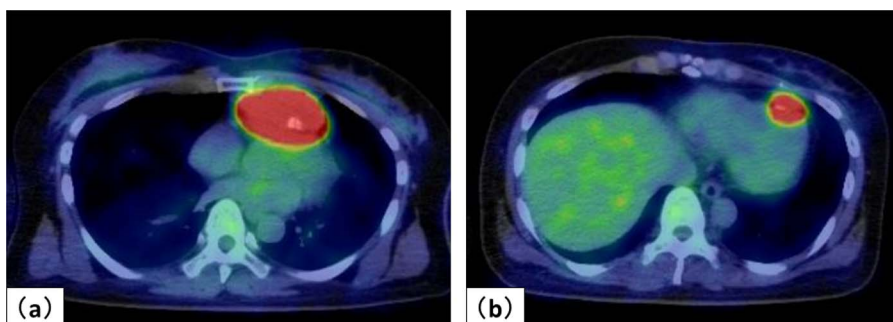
FDG-PET images showed uptake in the 2 masses. The maximum standardized uptake value (SUV) of 2 lesions were (a) 26.0 and (b) 13.6.
